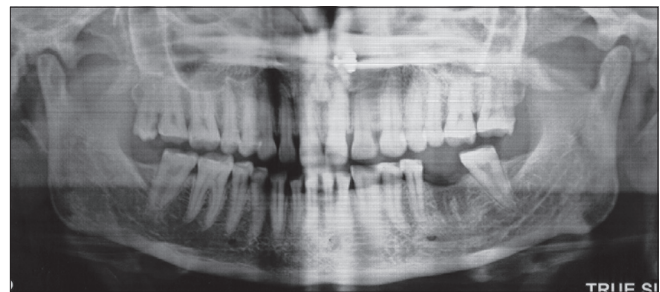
Patient 3: Panoramic radiograph
